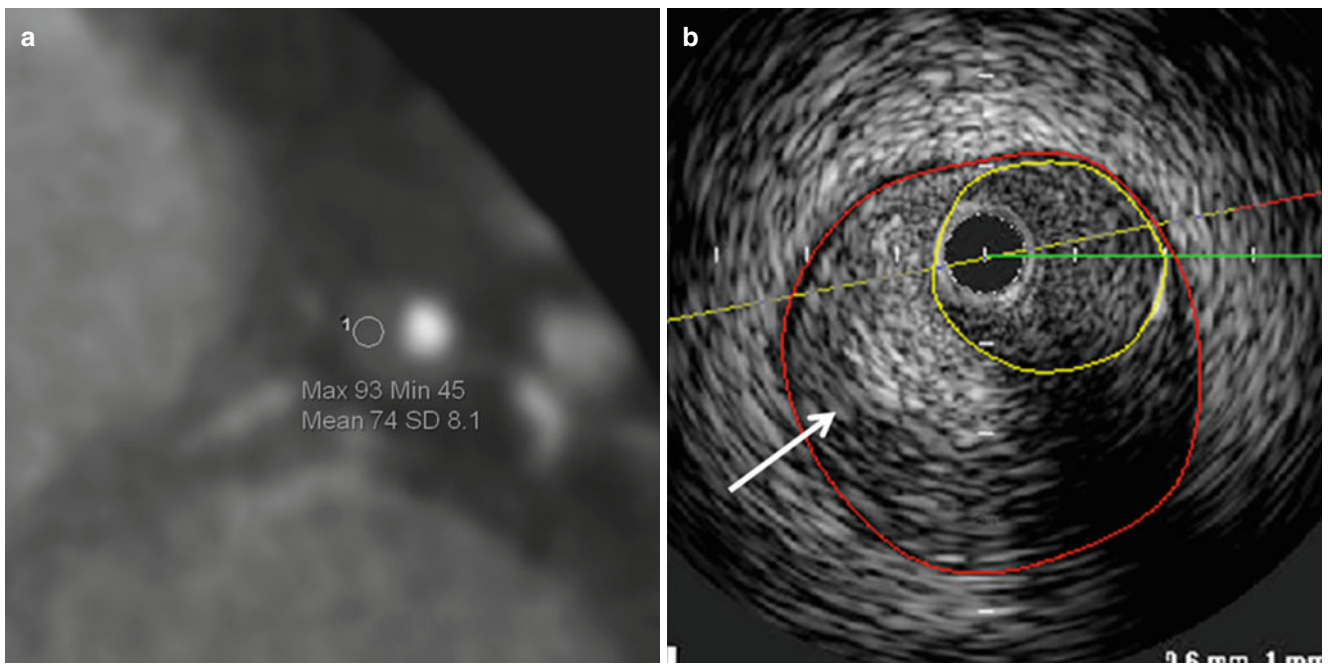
Plaque density measurement of fibrous plaque. (a) Cross-sectional image of coronary CT angiography (CCTA) shows non-calcified plaque. The mean CT density value in a region of interest
